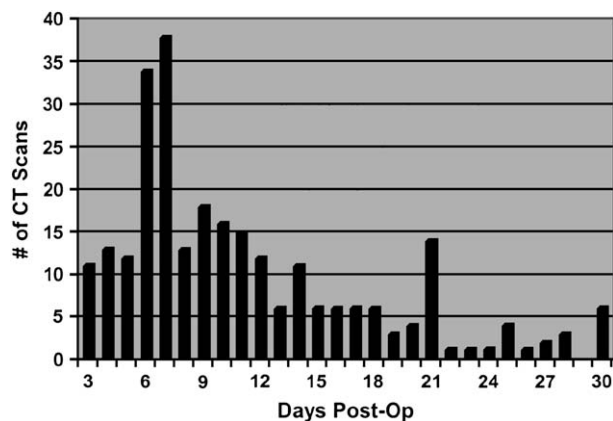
Computed tomographic studies by postoperative interval.
